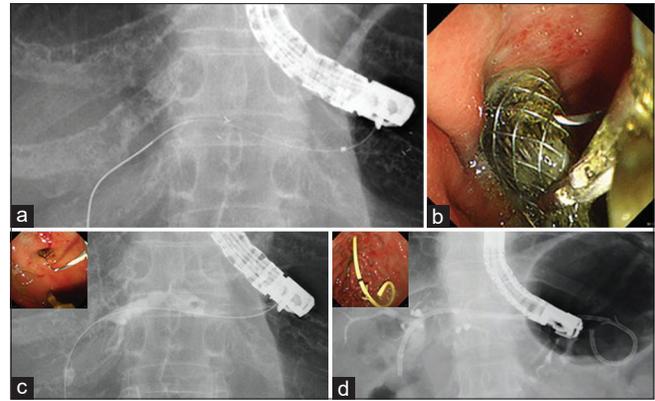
(a) A guidewire is inserted into the biliary tract through the endoscopic ultrasound-guided hepaticogastrostomy stent. (b) The metal stent is removed using a forceps biopsy device. (c) The guidewire is still placed in the biliary tract. (d) Plastic stent deployment is performed
